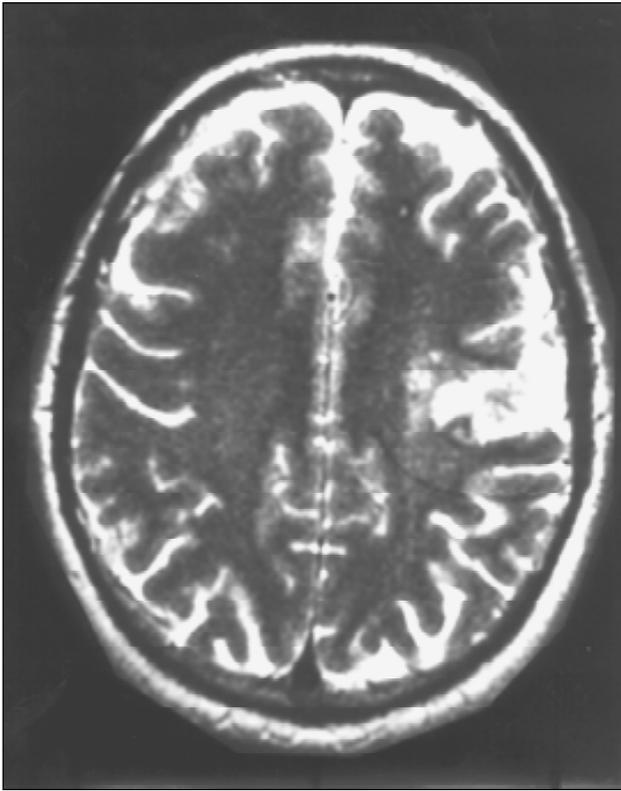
An MRI study demonstrated a left frontoparietal area of infarction.
